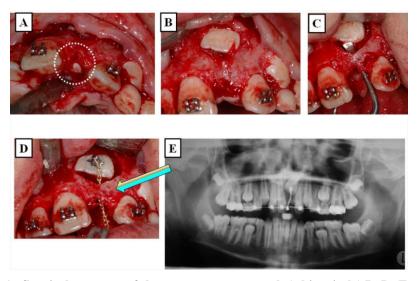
A–E:A: Surgical exposure of the supernumerary tooth (white circle).B–D: Extraction of the supernumerary tooth and exposure of tooth 21 with the creation of a tunnel for attachment placement.E: Radiographic image taken immediately after the surgical exposure.
